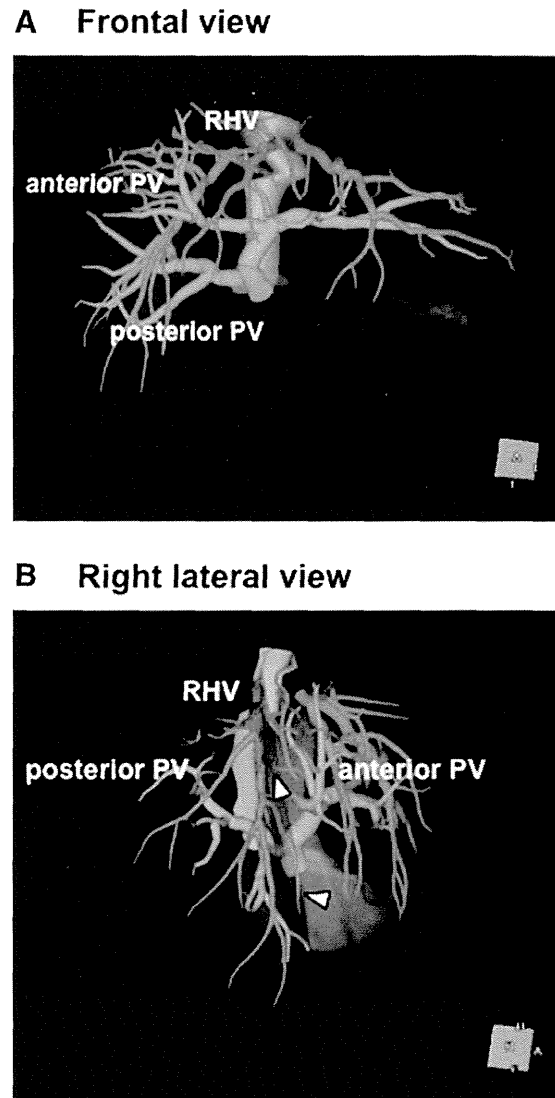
Representative cutting line on preoperative 3-dimensional CT. (A) Frontal view. (B) Right lateral view. The cutting line, which can be confirmed in panel B, lies between the RHV and the APV. The RHV branches that extend toward the right anterior sector (arrowheads) are preserved.
